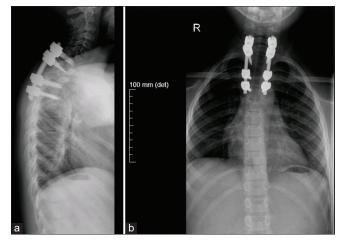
Seven-month post-operative radiographs: (a) Lateral and (b) anteroposterior view showing posterior spinal instrumentation maintained from T1 to T5 without signs of instability or sagittal and coronal malalignment.
